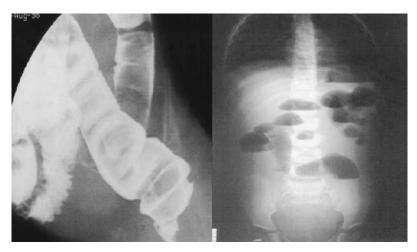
Abdominal radiographs from a 1month-old child with multiple endocrine neoplasia type IIA and Hirschsprung's disease. Note narrowing of rectosigmoid with proximal dilatation (*left*) and multiple dilated loops of small bowel with air-fluid levels (*right*). Reproduced with permission from Cohen MS et al.¹
